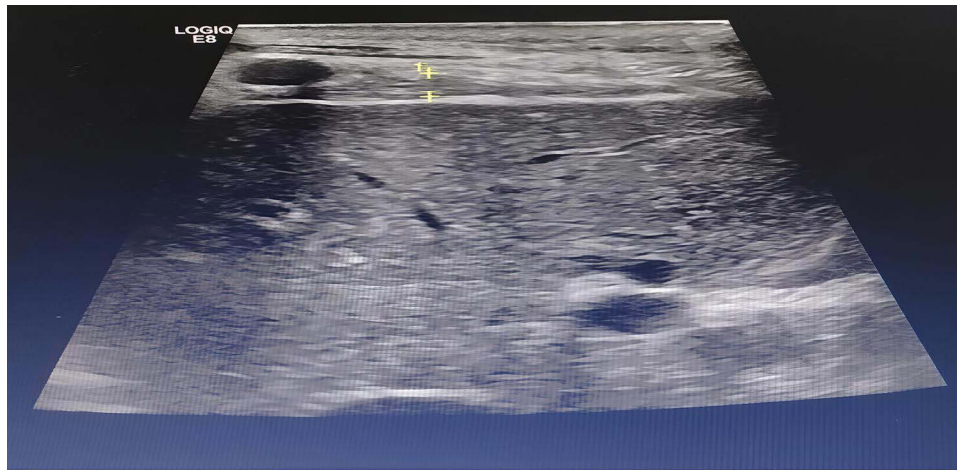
Ultrasonographic measurement of DTei. The diaphragm is visualized as a hypoechoic layer between two hyperechoic lines: the pleural line (superior) and the peritoneal line (inferior). Thickness is measured as the distance between these two lines at the end of inspiration.
